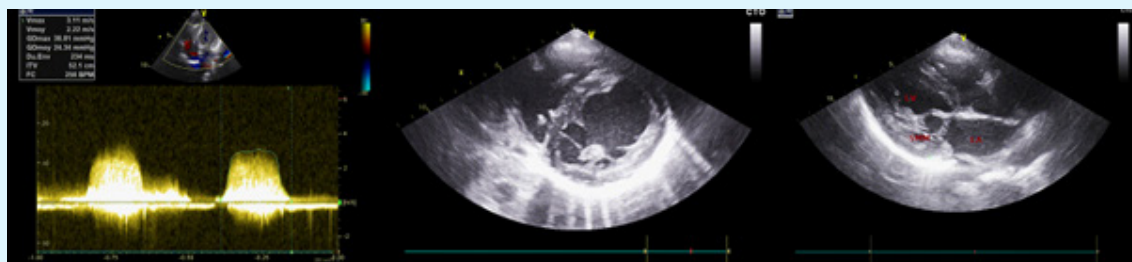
Multilevel mitral obstructions on Trans-thoracic echocardiography: supra mitral ring with mean gradient = 24 mmHg and parachute mitral valve. LA : left atrium, LV : left ventricle, SMM : supra mitral membrane.
